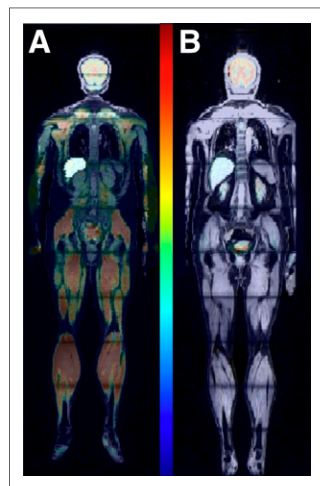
Whole-body assessment of tissue-specific insulin sensitivity with ^{18}F -FDG PET. (A) Healthy individual with M value of 15 (mg/kg-minute) with high tissue-specific glucose uptake; and (B) individual with type-2 diabetes with M value of 5 and low tissue-specific glucose uptake.
